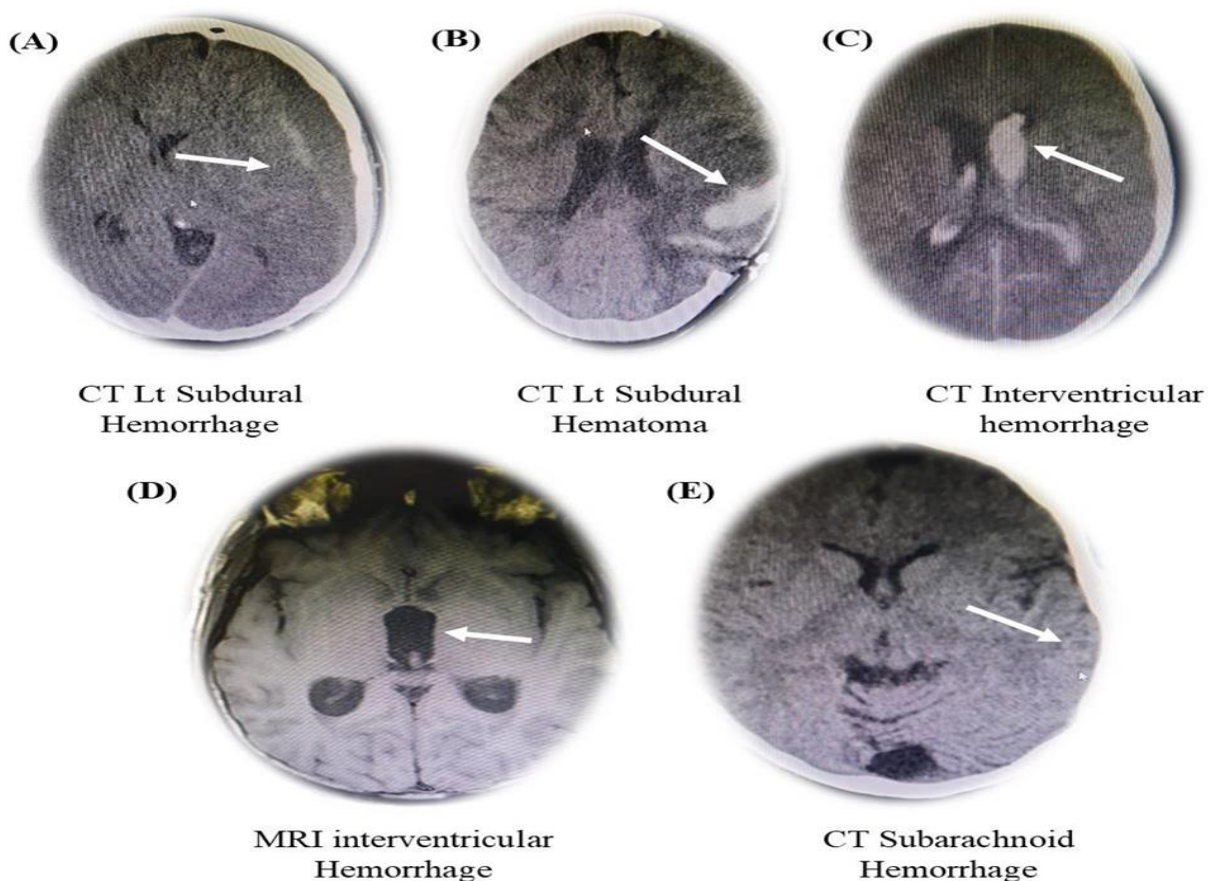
Represents the CT scan and MRI images of brain in case of acute intracerebral hemorrhage, Figure (1, A) shows the subdural hemorrhage, Figure (1, B) subdural hematoma, Figure (1, C) Interventricular hemorrhage, Figure (1, D) shows the brain image demonstrates the interventricular hemorrhage using MRI, while Figure (1, E) the subarachnoid hemorrhage using CT scan
